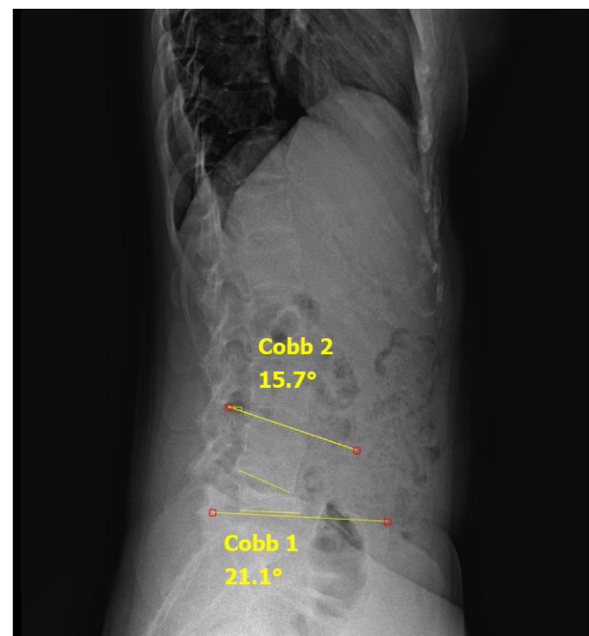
Local and Regional Kyphotic Angle based on Lateral Radiograph. The local kyphotic angle is 21.1° and regional kyphotic angle is 15.7°.
